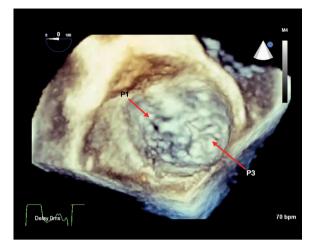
Left atrial enface view of the mitral valve using 3-dimensional transesophageal echocardiography with arrows pointing at restricted P1 and prolapsing P3.
